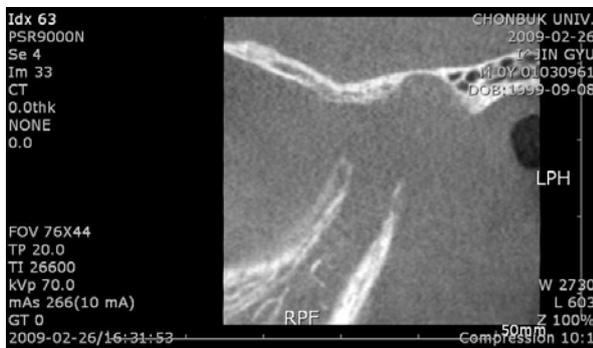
Sagittal view of left mandibular condyle by cone beam CT.
